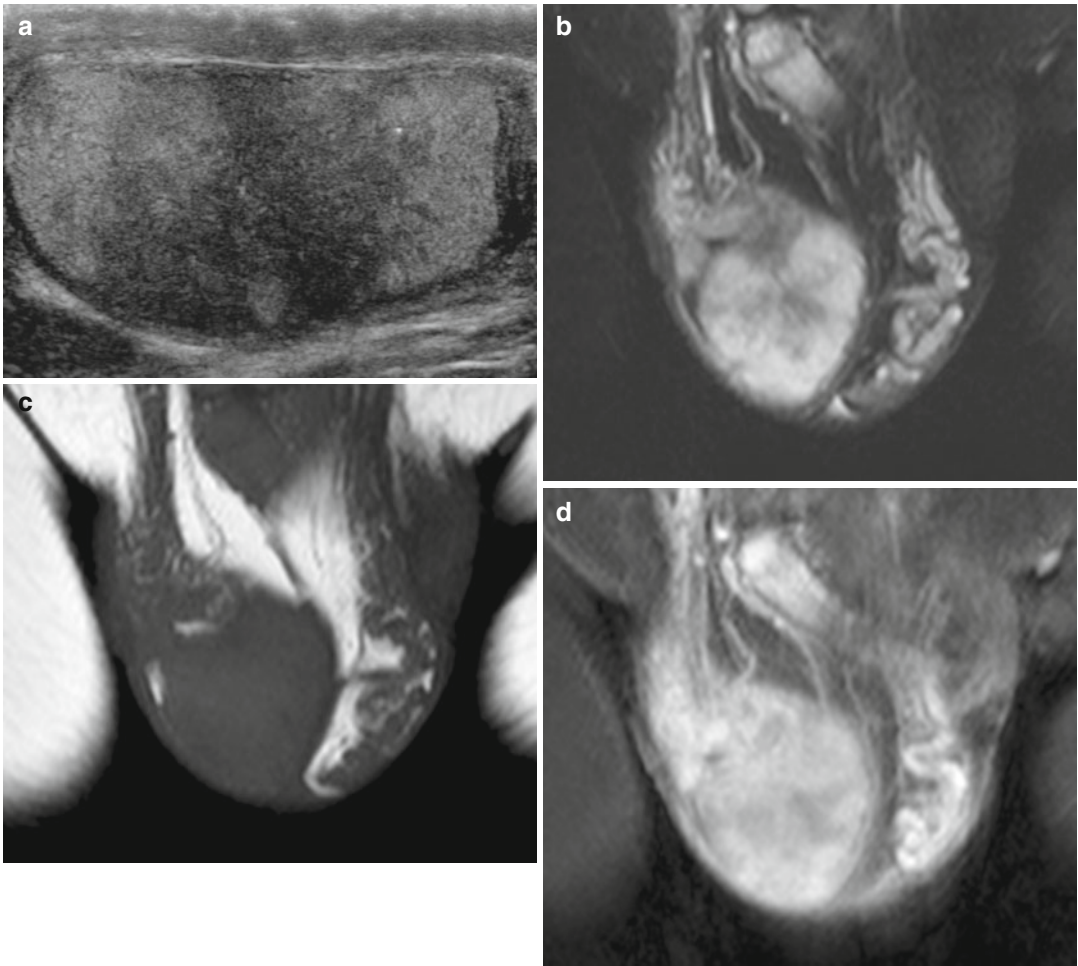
MR investigation of a patient with inconclusive ultrasonographic scan. (a) Grayscale ultrasonography shows a markedly inhomogeneous right testis. (b–d)
